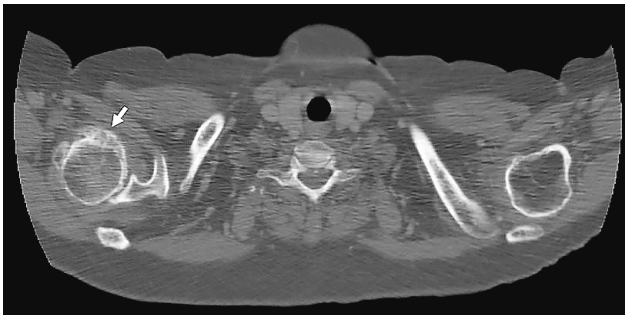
The arrow shows an osteophyte on the humeral head in an axial image of a shoulder joint on contrast-enhanced computed tomography.
